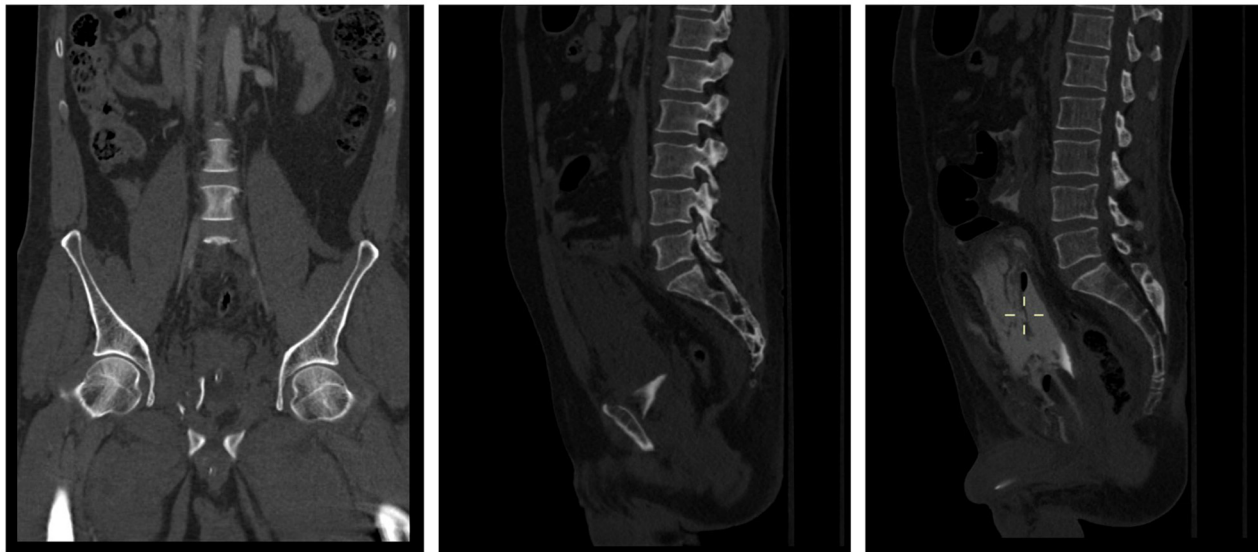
A coronal and sagittal computed tomography views showing the detached bone segment and extravasation of contrast.
